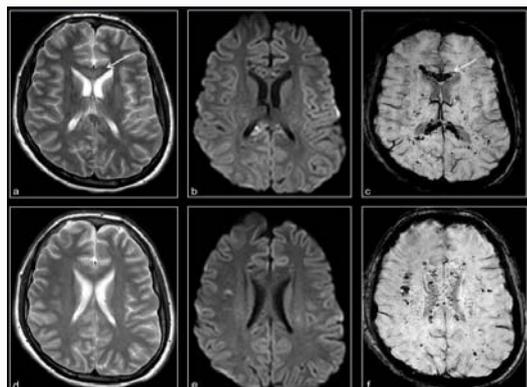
Axial T2wTSE (a, d) with demonstration of signal enhancements in the corpus callosum (arrow), hyperintense compared with the white matter. No increased signal intensity in isoB1000 (b, e) as evidence of a diffusion disorder of the brain tissue. On the susceptibility-weighted images (SWI) (c, f), the T2-weighted signal increases correspond to a signal cancellation (arrow). Demonstration of multiple susceptibility artefacts in the periventricular white matter. The changes correspond to multiple hemosiderin deposits and are interpreted as critical illness-associated microbleeds.
